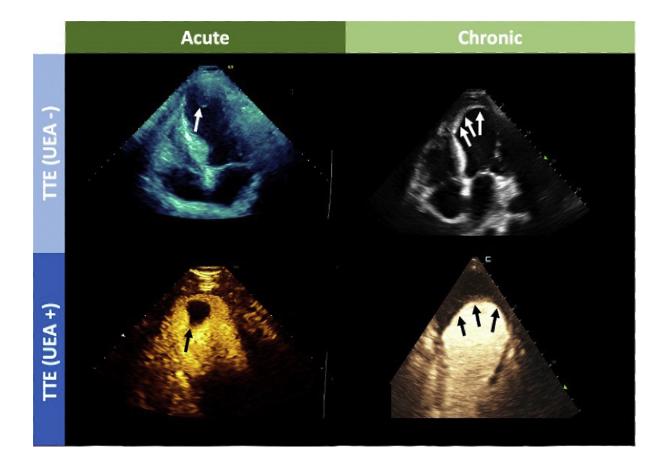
Visual representation of acute and chronic left ventricular thrombi: Acute and chronic left ventricular thrombi as seen by transthoracic echocardiography (TTE) with and without an ultrasound-enhancing agent (UEA). Single arrows (black and white) depict acute thrombus formation characterised as a protruding apical mass. Triple arrows (black and white) show chronic thrombus formation characterised as a smooth, laminar apical mass. Black and white arrows show thrombus detected by TTE with and without the use of a UEA, respectively. Extracted from (3).
